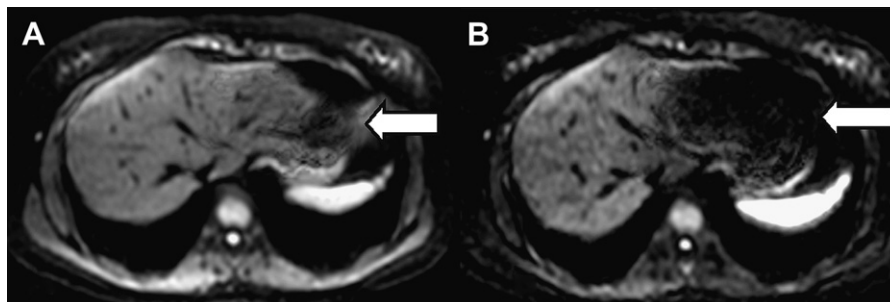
Respiratory-triggered DWI, but not cardiac triggered. White arrows indicate cardiac motion artifact. (A) $b = 150 \text{ s/mm}^2$ and $TE = 54 \text{ ms}$; (B) $b = 600 \text{ s/mm}^2$ and $TE = 68 \text{ ms}$.
